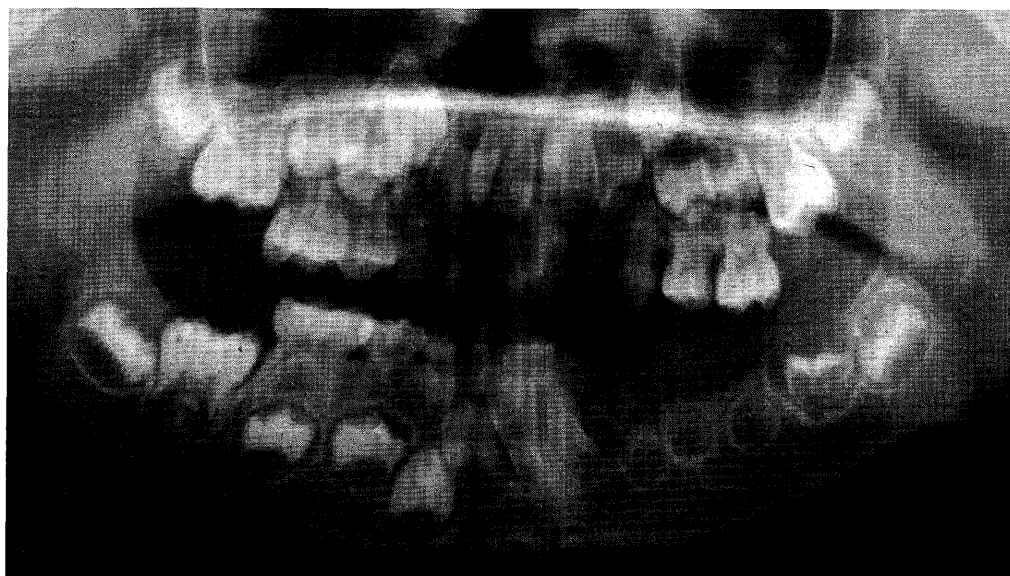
Panoramic x-ray at the age of 5 years and 10 months showing calcification of the affected mandibular left permanent teeth. The tooth germs of mandibular left premolars were small and hypoplastic, with an indistinct crown. Although the crown formation of the mandibular left first molar was almost finished, the tooth was surrounded by a pericoronal radiolucency representing an enlarged follicle, and the demarcation between enamel and dentine was poorly defined.
